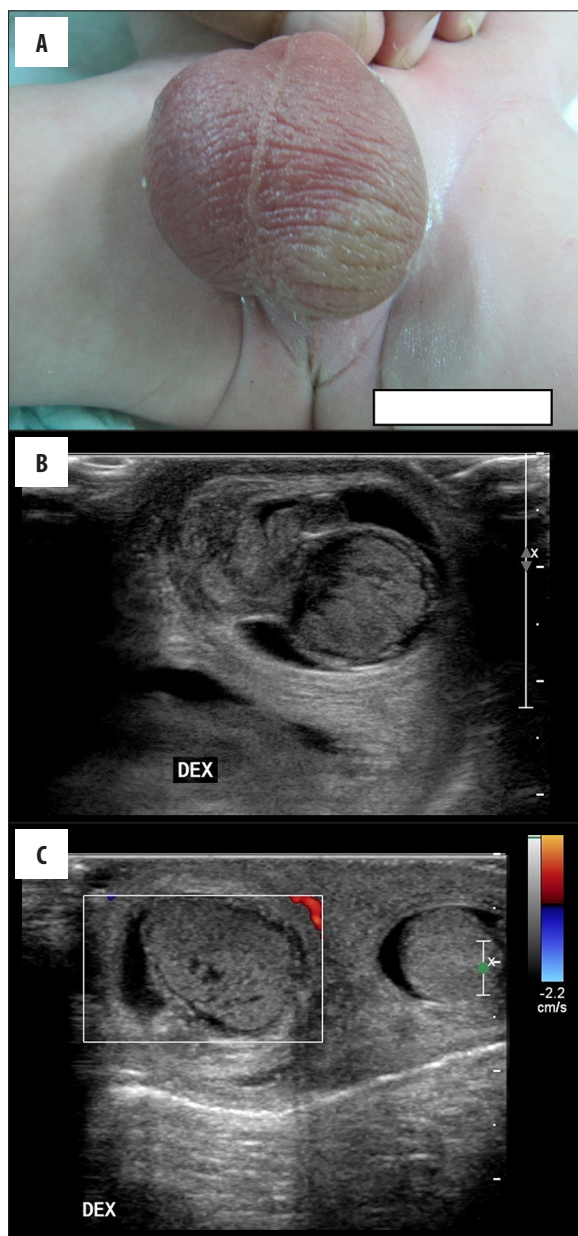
Newborn in the 1-st day of life with swelling and redness of the right hemi-scrotum (A). Ultrasonography revealed enlarged and heterogenous right testicle (B), without blood flow in Doppler ultrasonography (C). Intraoperative findings confirmed right testicle necrosis (D). For comparison – normal left testicle in the same patient, with blood flow visualized in several vessels (E).
